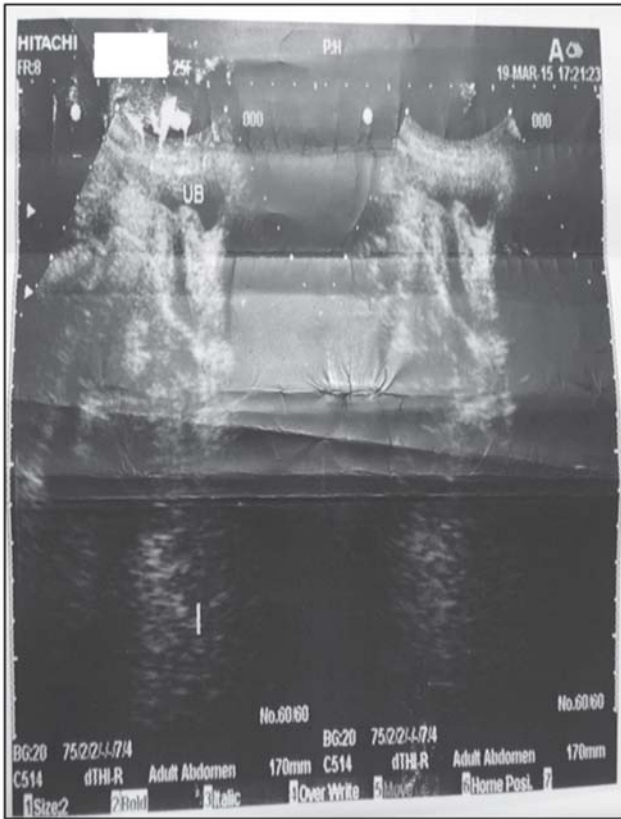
Ultrasound image of the tubular structure behind the urinary bladder.
